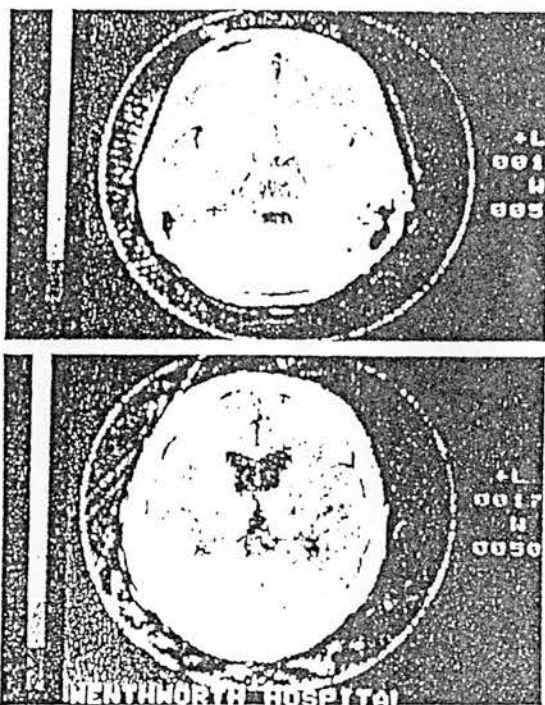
Cerebral CT showing (above) an area of decreased density in the pontine region; and (below) a calcific focus in the proximity of the pineal gland.
